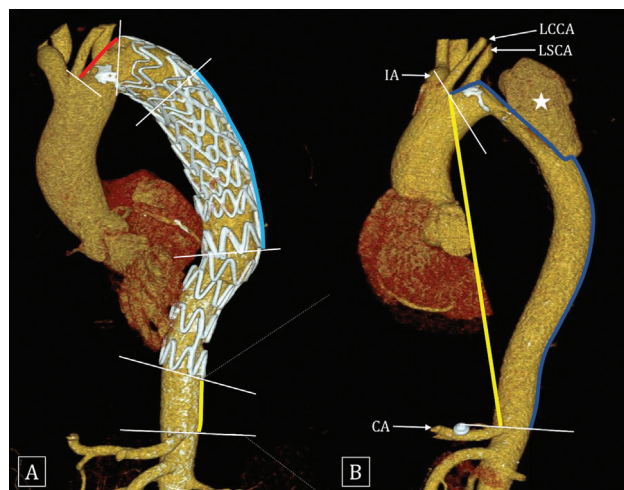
Volume rendered computed tomography (CT) images show the measurements used in this study. Distance between left common carotid artery (LCCA) and proximal-most point of stent graft (red line in A) was measured for proximal migration. Distance between the distal-most part of stent graft (yellow line in A) and carotid artery (CA) was measured for distal migration. An overlapping segment of the multiple stent grafts (blue line in A) was measured for the migration of an overlapping segment. The tortuosity index was calculated by dividing the distance between LCCA and CA (blue line in B) with straight distance (yellow line in B) between the same two landmarks. All the distances were taken along the greater curvature of the aorta. Sac of the pseudoaneurysm (asterisk) is noted in B.
